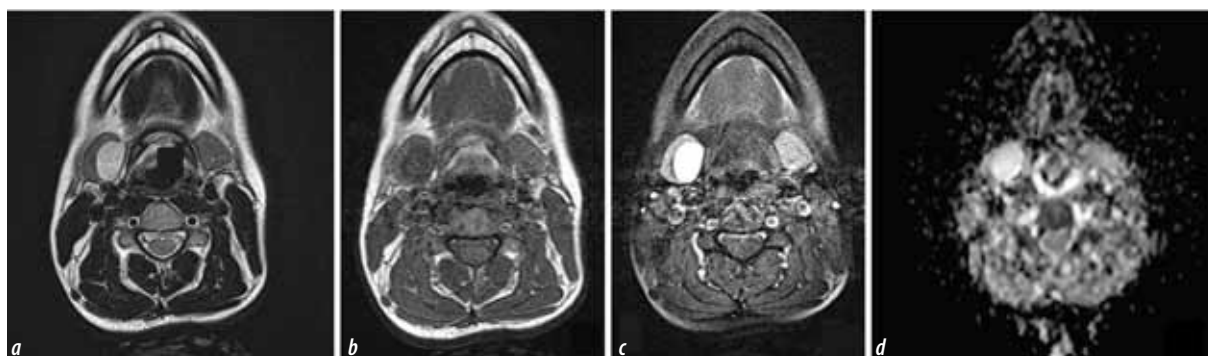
MRI axial section of the neck showing NF in the right submandibular gland with similar features of PA:
